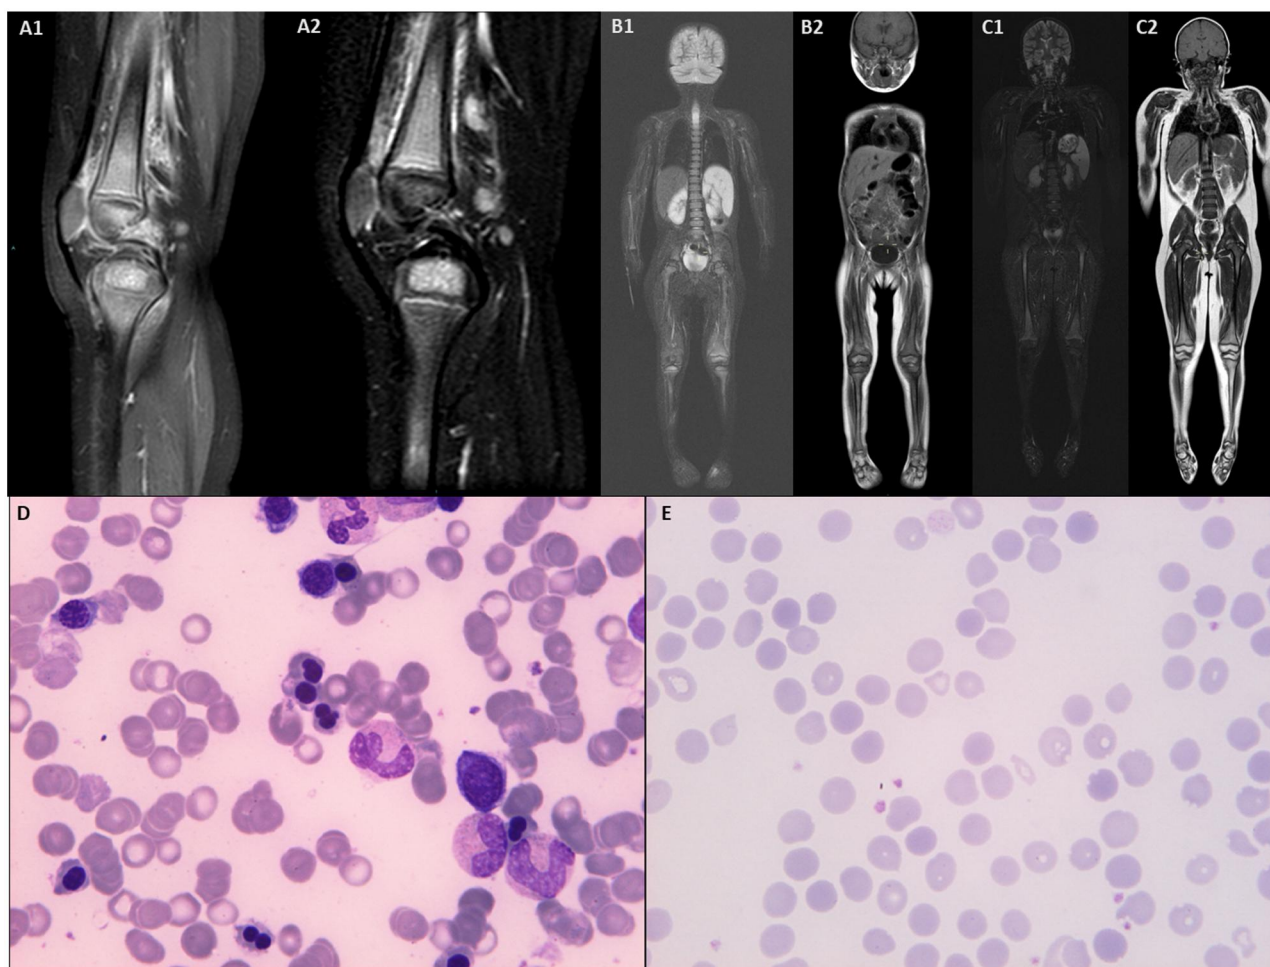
MRI images and bone marrow smears of the described patient before (A1, A2, B1, B2 and D) and after (C1, C2 and E) the beginning of treatment with IL1-blockers. (A) Coronal Mobiview reconstruction of turbo-spin-echo (TSE) short time inversion recovery (STIR) and TSE T1 multistack acquisition. Note bilateral meta diaphyseal distal femoral oedema as medullary diffuse hyper-hypointensity in STIR/T1. (B) Sagittal TSE t1 fat sat post contrast medium (CM) and TSE T2 fat sat sequence confirms oedema of the distal femoral metaphysis with periosteal and articular contrast enhancement. (C) Coronal Mobiview reconstruction of TSE STIR and TSE T1 multistack acquisition. Note the complete resolution of the meta diaphyseal distal femoral oedema. (D) Bone marrow dyserythropoiesis, with typical morphological abnormalities represented by numerous bi-plurinuclear erythroblasts, intercytoplasmic bridges, extranuclear chromatin. Myeloid series and megakaryocytes normorepresented. (E) Follow-up 6 months after starting anti-IL-1RI therapy: marked improvement in the picture with only a few elements compatible with dyserythropoiesis
